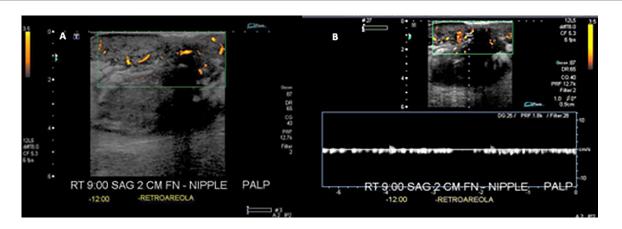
(Patient no. 2): Ultrasound with color Doppler of right breast at 9 o'clock location shows multiple, solid, hypoechoic, partially circumscribed and partially coalescing, with parallel orientation and dense posterior acoustic shadowing (A). There is internal and peripheral vascularity on color Doppler, which on spectral analysis (B) displays a very low flow, venous pattern.
